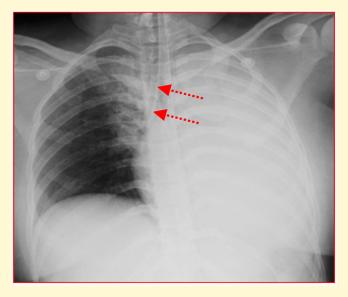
Frontal chest radiographs show ET tube in the right main bronchus and collapse of the left lung.
